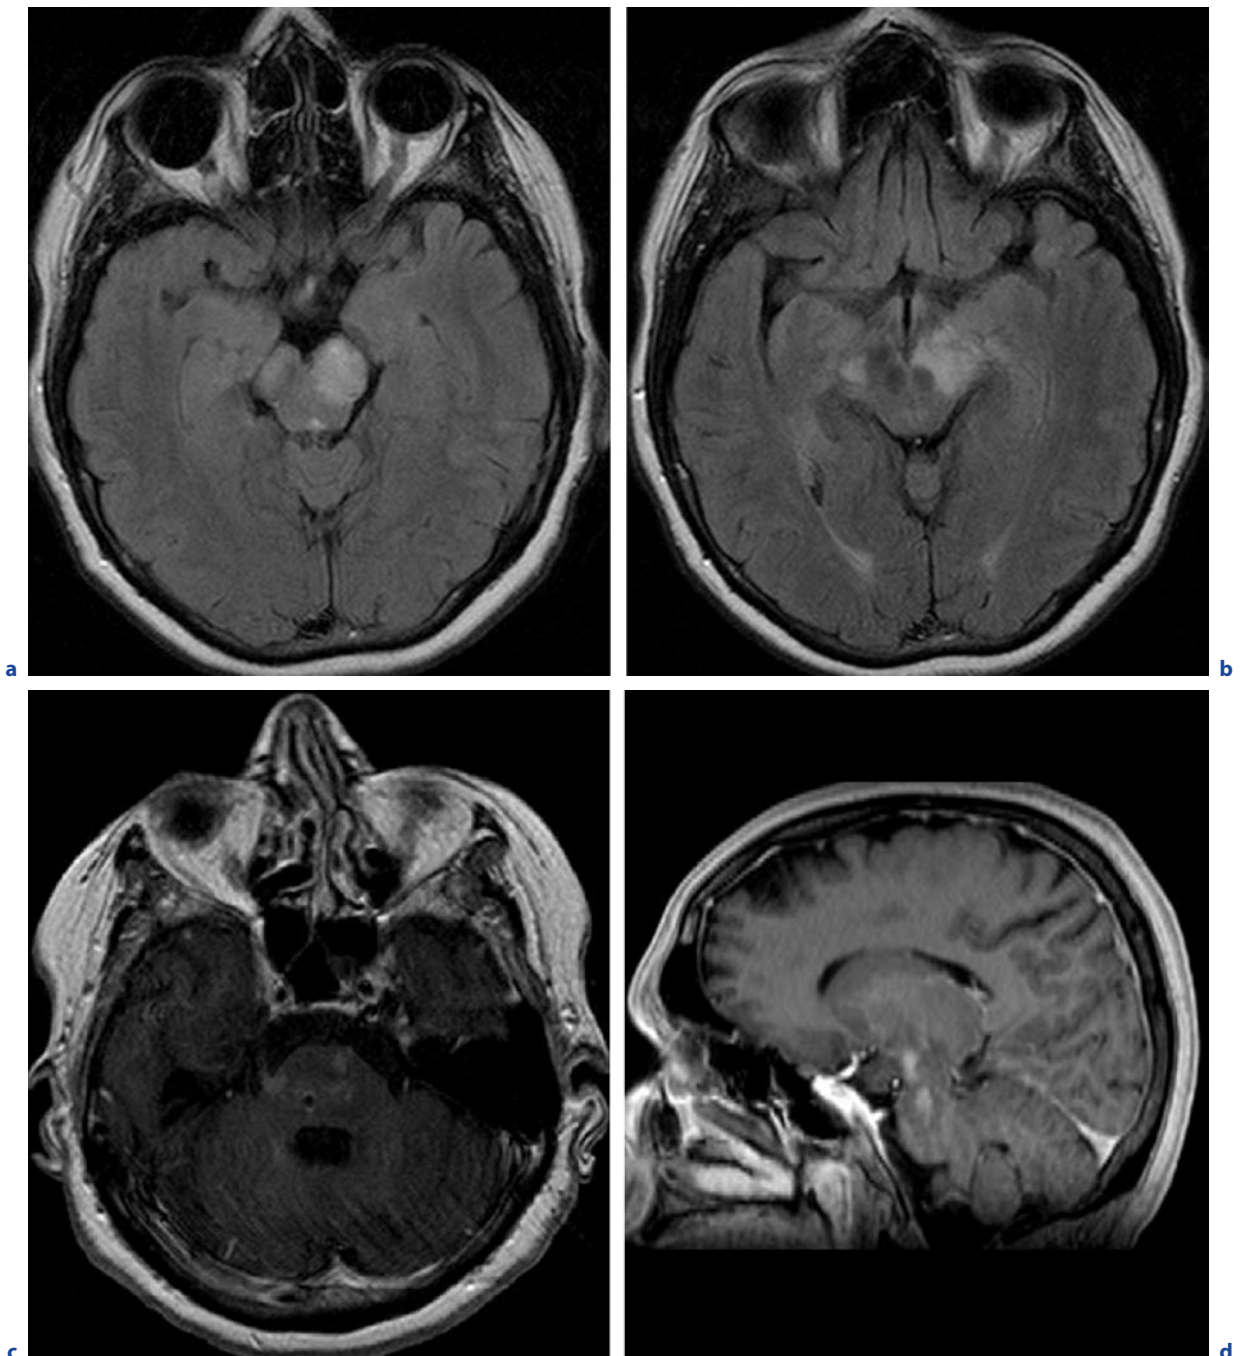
Behçet's disease. A 56-year-old woman with dysarthria and labile affect due to brain-stem encephalitis associated with neuro-Behçet syndrome. a,b Axial FLAIR images. c Axial T1-weighted image after contrast administration.
